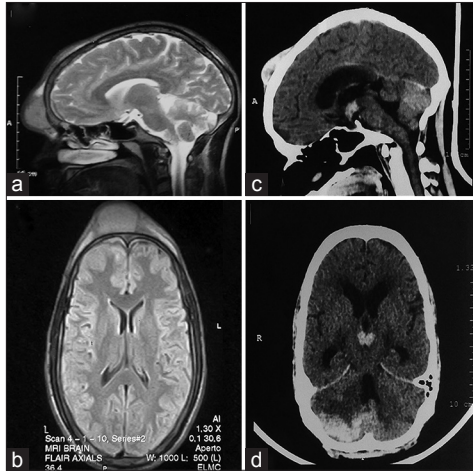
Radiographic examination of the lesion. (a and b) Magnetic resonance imaging of head, sagittal T2-weighted (a) and axial fluid-attenuated inversion-recovery (b) sequence pretreatment study, showing well-defined hyper intense lesion over scalp in right frontal region. (c and d) Enhanced brain computed tomographic sagittal (c) and axial (d) scan during treatment study, demonstrating the residual lesion over fronto-parietal convexity and newly appeared ill-defined heterogeneously enhanced hyperdense lesions with perilesional edema in right cerebellar hemisphere and suprasellar region with mass effect in form of hydrocephalus
